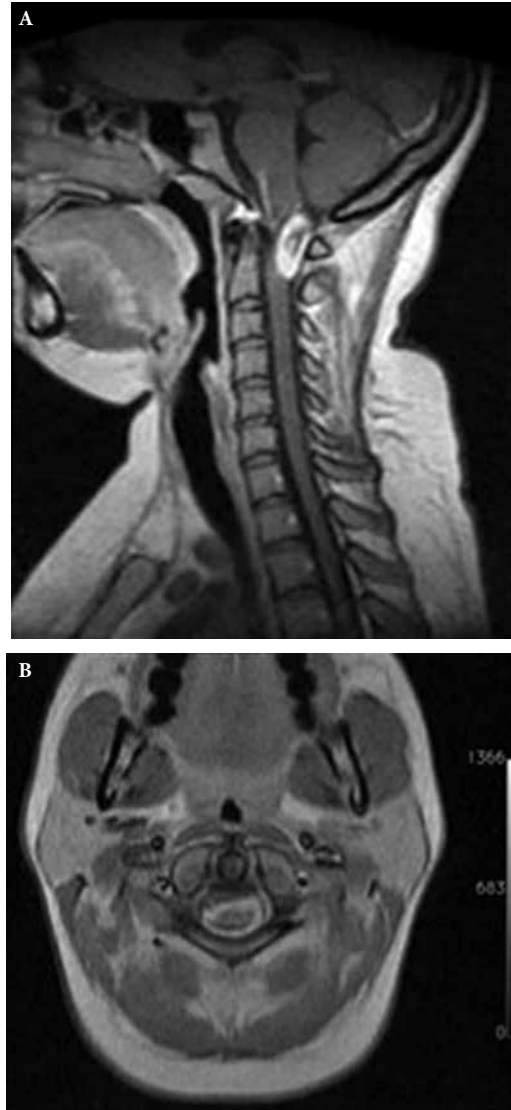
A (T1) Weighted sagittal plane MRI showing the lesion, enhanced after administration of gadolinium. B (T2) - Weighted axial plane MRI.
